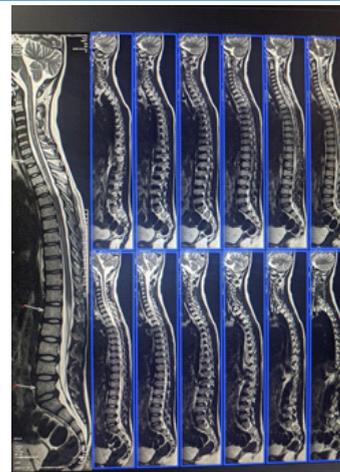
SHOWING NORMAL MRI WITH MARKERS AT LEVELS
